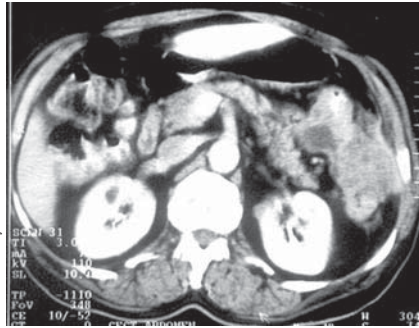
CT scan showing carcinoma of splenic flexure with local extramural and abdominal wall invasion
